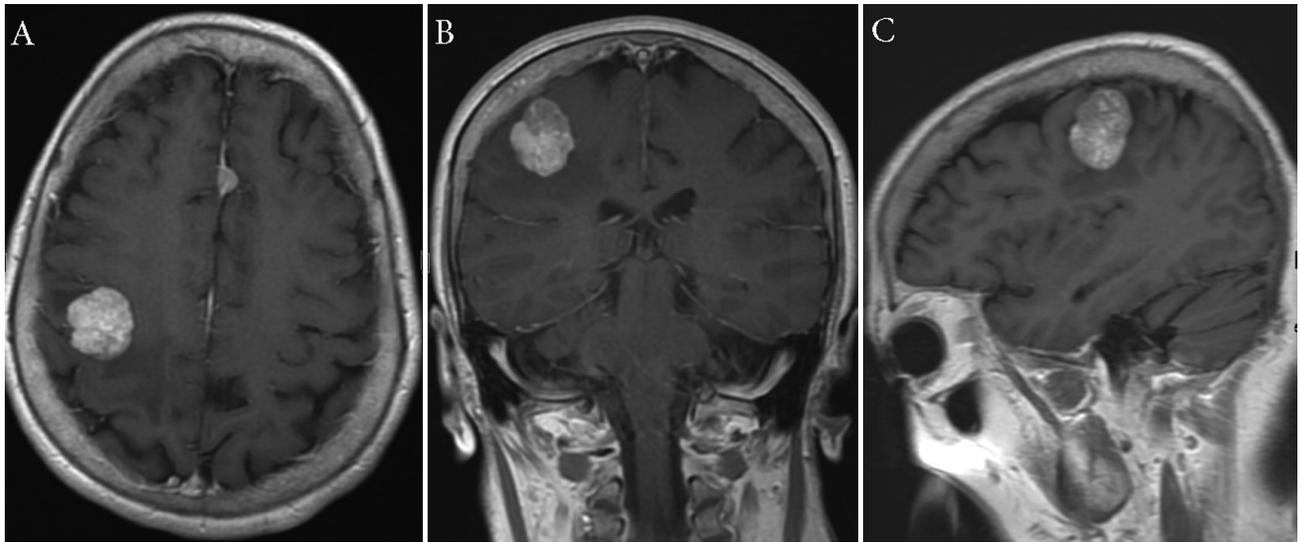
T1-weighted postcontrast axial (A), coronal (B), and sagittal (C) MR images demonstrating the tumor within the right central sulcus.
